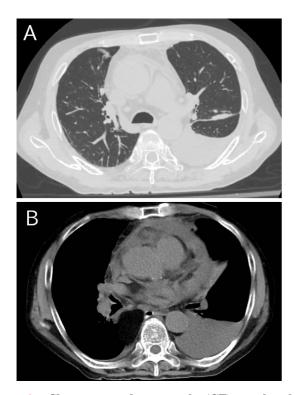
Chest computed tomography (CT) reveals pulmonary infiltrate in the right upper lobe and left pleural effusion (A). Chest CT reveals a large amount of pericardial and left pleural effusion (B).
